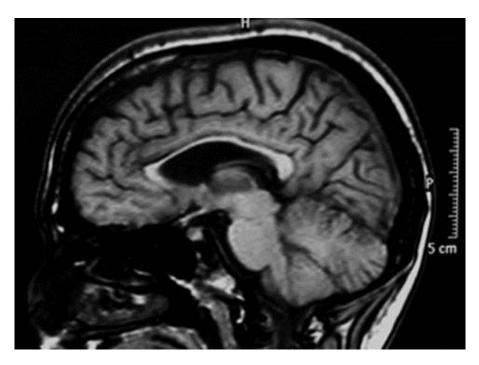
Thinning of corpus callosum on the patient's sagittal MRI image.
